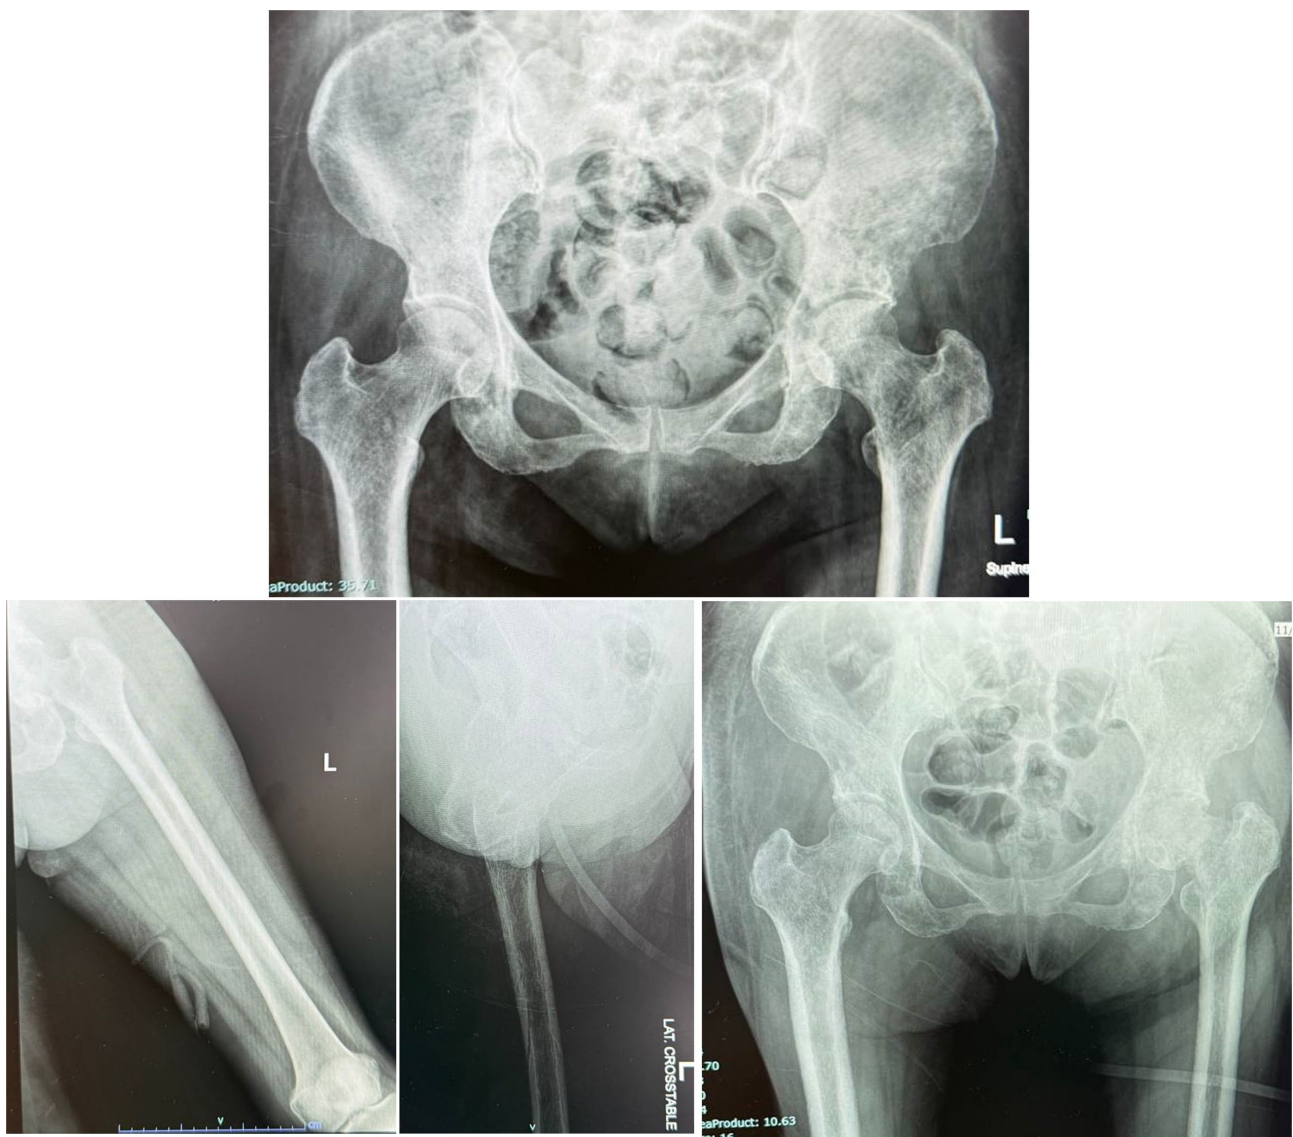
Plain X-rays films on first check up and subsequent follow up of the patient showing a pathologic neck fracture of the left femur.
